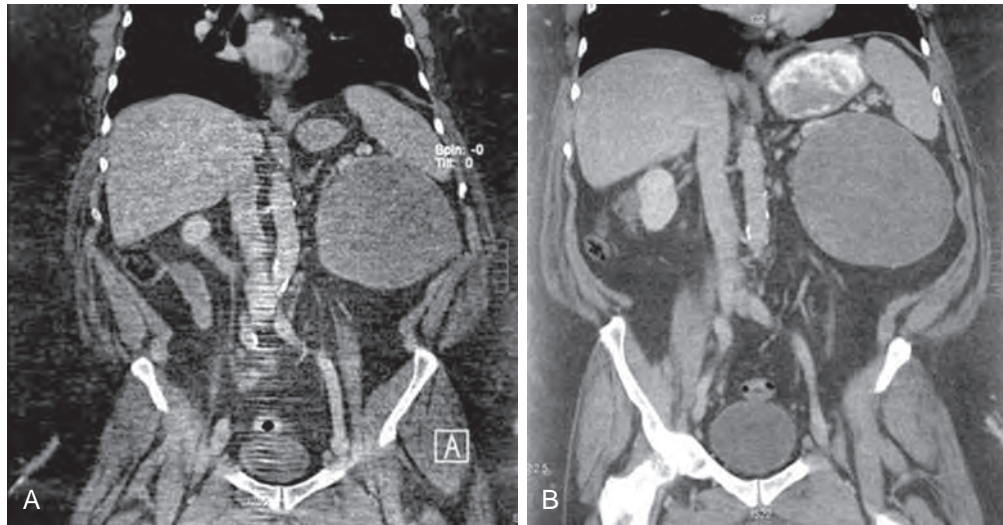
A. Coronal CT images of 56-year-old patient (body weight, 91 kg) with routine contrast-enhanced CT in portal venous phase (120 kVp; noise index, 15; automatic tube current, 150-550 mA) performed with filtered back projection technique shows increased image noise and artifact. B. In the same patient, CT done at different time point using ASIR reconstruction (120 kVp; noise index, 19; automatic tube current, 150-450 mA) shows improved image noise and image quality and substantially reduced artifacts.
